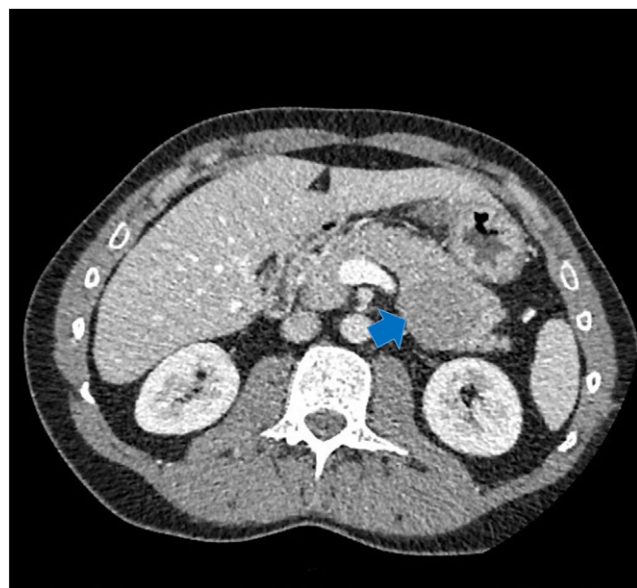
P 17 ▲ Computed tomography (CT) imaging of the pancreatic tumor. CT scan revealed a solid tumor of the caudal pancreas (arrow)
